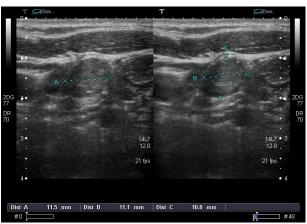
Ultrasonography was performed four months after radioiodine ablation and revealed a round lymph node at level III. The greatest measured diameter was 11.5 mm.
